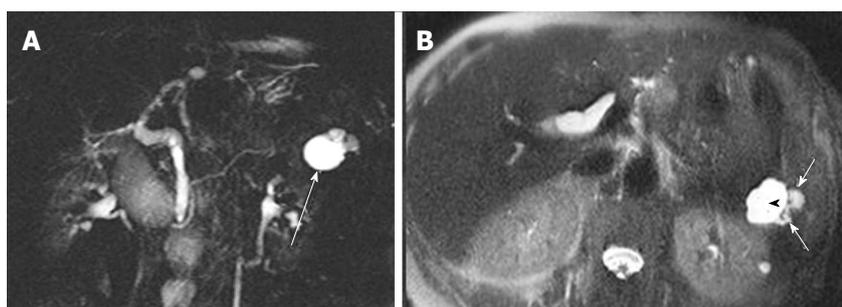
A 61-year-old female with oligocystic serous cystic neoplasm showing a cyst-by-cyst pattern. A: Magnetic resonance cholangiopancreatography demonstrates a cystic mass (arrow) in the pancreatic tail consisting of a macrocyst and two adjacent smaller cysts; B: Axial T2-weighted single-shot fast spin-echo magnetic resonance image shows a lobulated macrocyst (arrowhead) with adjacent smaller cysts (small arrows) in the pancreatic tail (cyst-by-cyst pattern).
